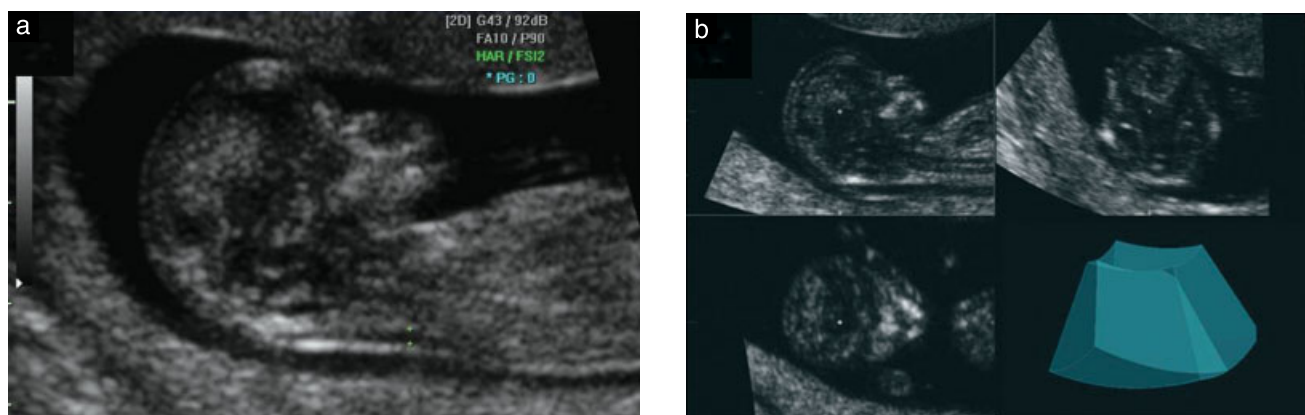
(a) For two-dimensional (2D) sonographic nuchal translucency thickness (NT) measurement, the investigator acquired a mid-sagittal plane according to the standards established by Nicolaides *et al.*¹¹. (b) For NT measurement using the three-dimensional (3D) technique, 3D volumes were displayed in the three orthogonal planes that compose the multiplanar mode, and axes were adjusted to obtain the correct mid-sagittal plane.
